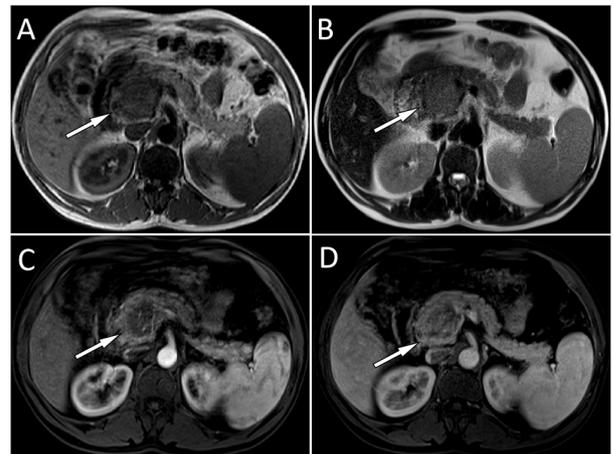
Abdominal magnetic resonance imaging showed an abnormal signal shadow of ~1.2x1.0 cm in the head of the pancreas (arrows), with (A) a slightly low signal on T1WI and (B) equal signaling on T2WI. On contrast-enhanced T1WI, the signaling of the lesion was slightly weaker than that of the peripheral normal pancreatic parenchyma in the (C) arterial and (D) venous phases. WI, weighted imaging.
